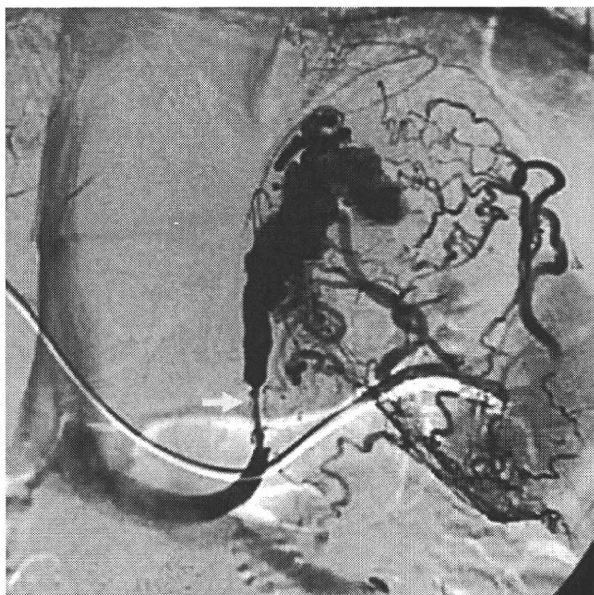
A portogram showing a gastroduodenal shunt (GRS) with a linear stricture (arrow). Neither ultrasound nor contrast-enhanced computed tomography demonstrated GRS in this case.
